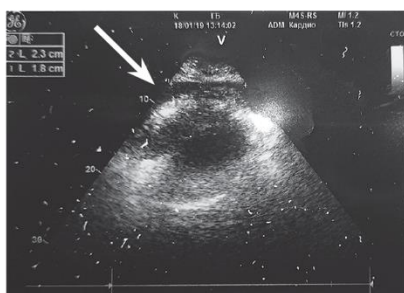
The ultrasound of the pericardial cavity. The white arrow indicates uncoupling of pericardial leaflets
